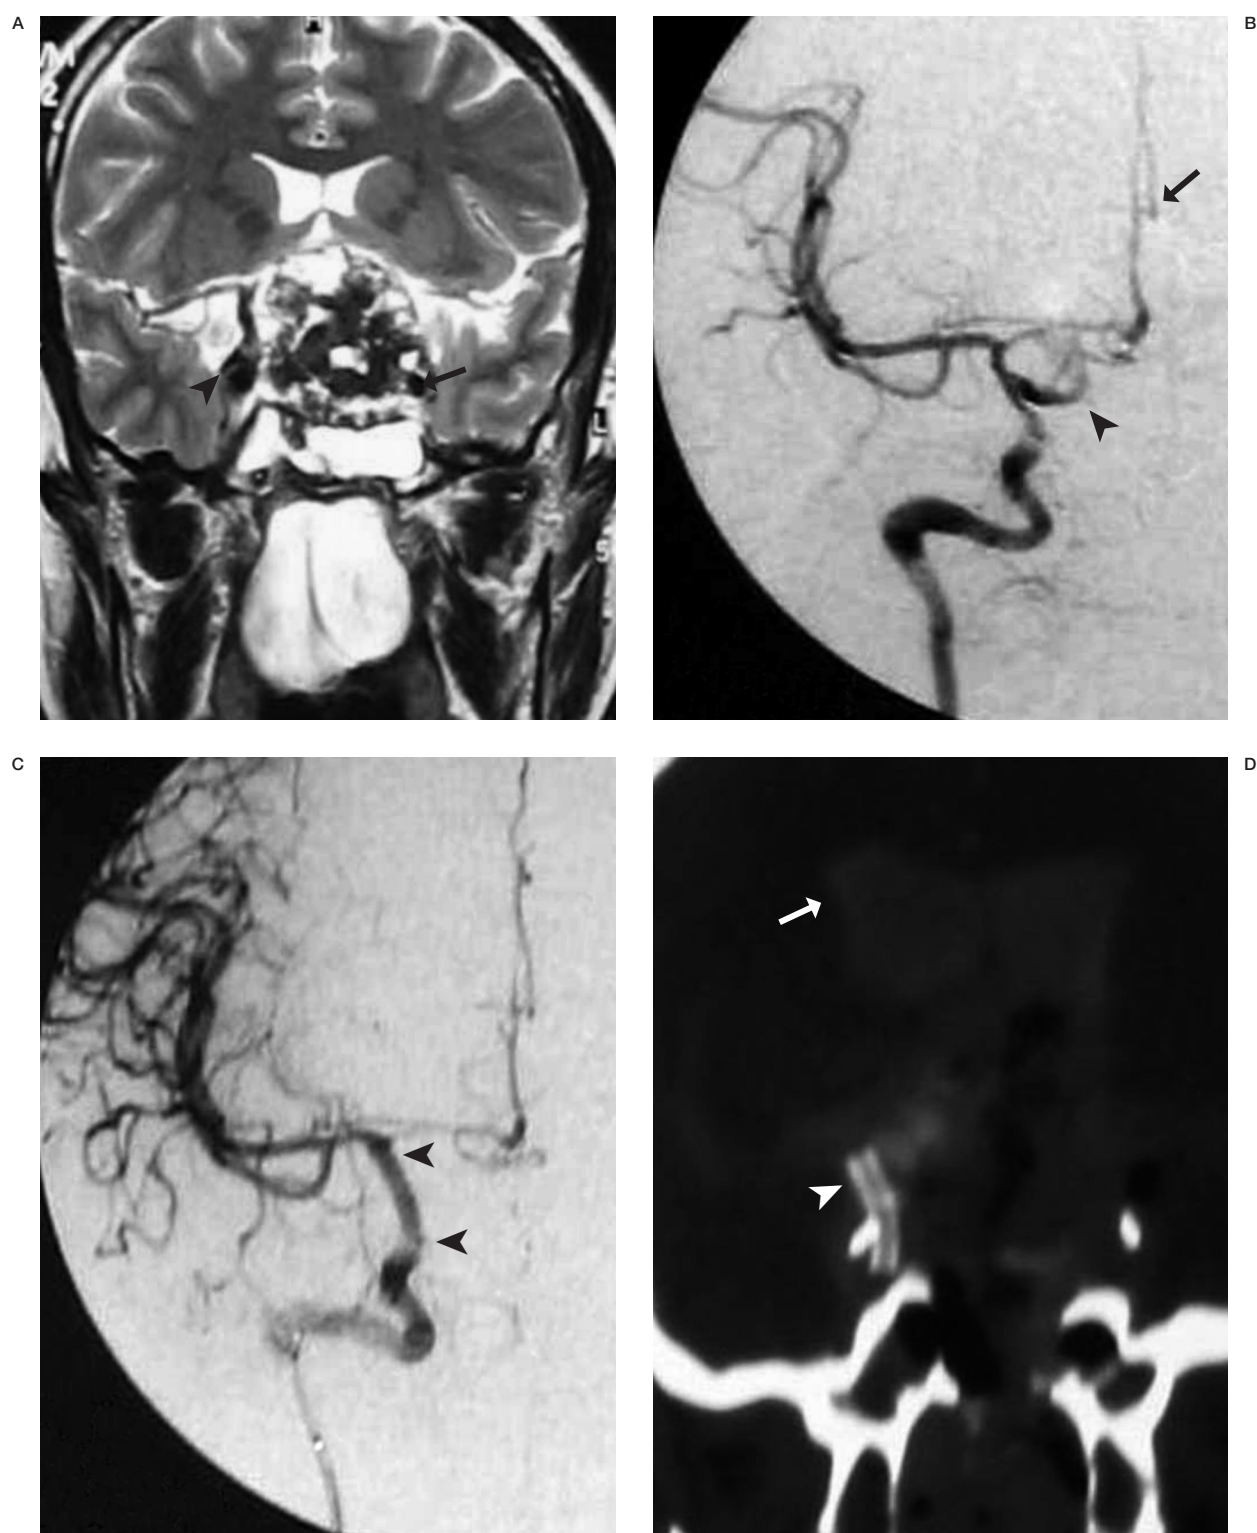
A) Coronal MRI of brain showed craniopharyngioma contiguous with the medial wall of the supraclinoid right ICA (arrowhead) left ICA encased (arrow). B) Right ICA angiogram showed extravasation from the medial wall supraclinoid segment (arrow head). The A1 segment is elevated superiorly and ACA is bihemispheric (arrow). C) Post-angioplasty right ICA angiogram shows smooth, parallel walled supraclinoid ICA (arrowheads) with no extravasation. D) Post-angioplasty coronal CT scan shows the stent (arrowhead) with extensive intraventricular hemorrhage (arrow).
